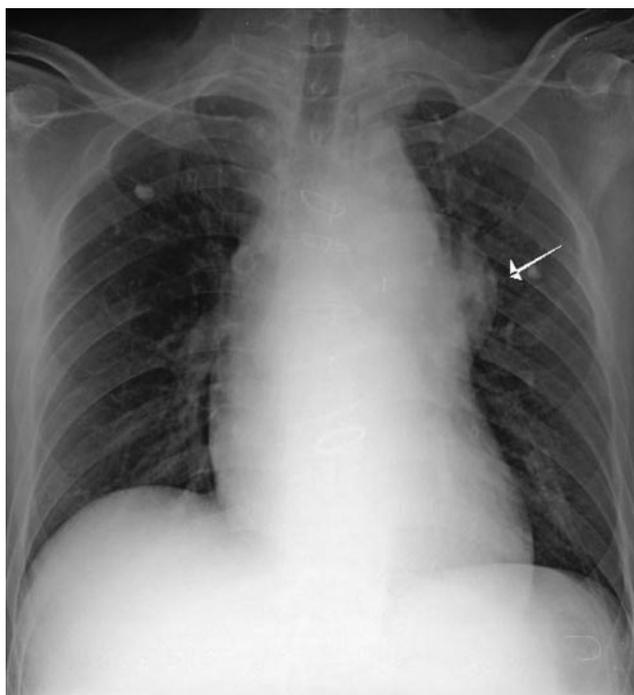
Initial chest x-ray showed mediastinal enlargement with hilar shadow (arrow).
